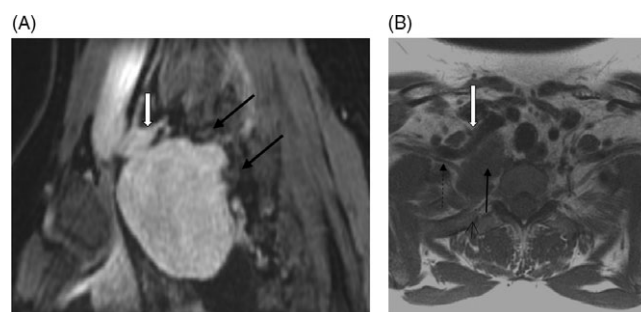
(A) Sagittal post-Gadolinium 3D MRI – Axial fat saturated spoiled gradient image demonstrates the mass bulging posteriorly in between the first and second ribs (thin black arrows). The mass is seen just posterior and slightly below the right subclavian artery (white arrow) at the level of the origin of the vertebral artery, involving the expected location of the stellate ganglion. (B) Axial T1 image at the thoracic inlet demonstrates the mass in the posterior mediastinum (thin black arrow). It is posterior to the right subclavian artery (white arrow) and anterior to the neck of the right first rib (short black arrow). This location would be in the expected vicinity of the stellate ganglion. It is intimately associated with the right C8 nerve root (dashed arrow).
